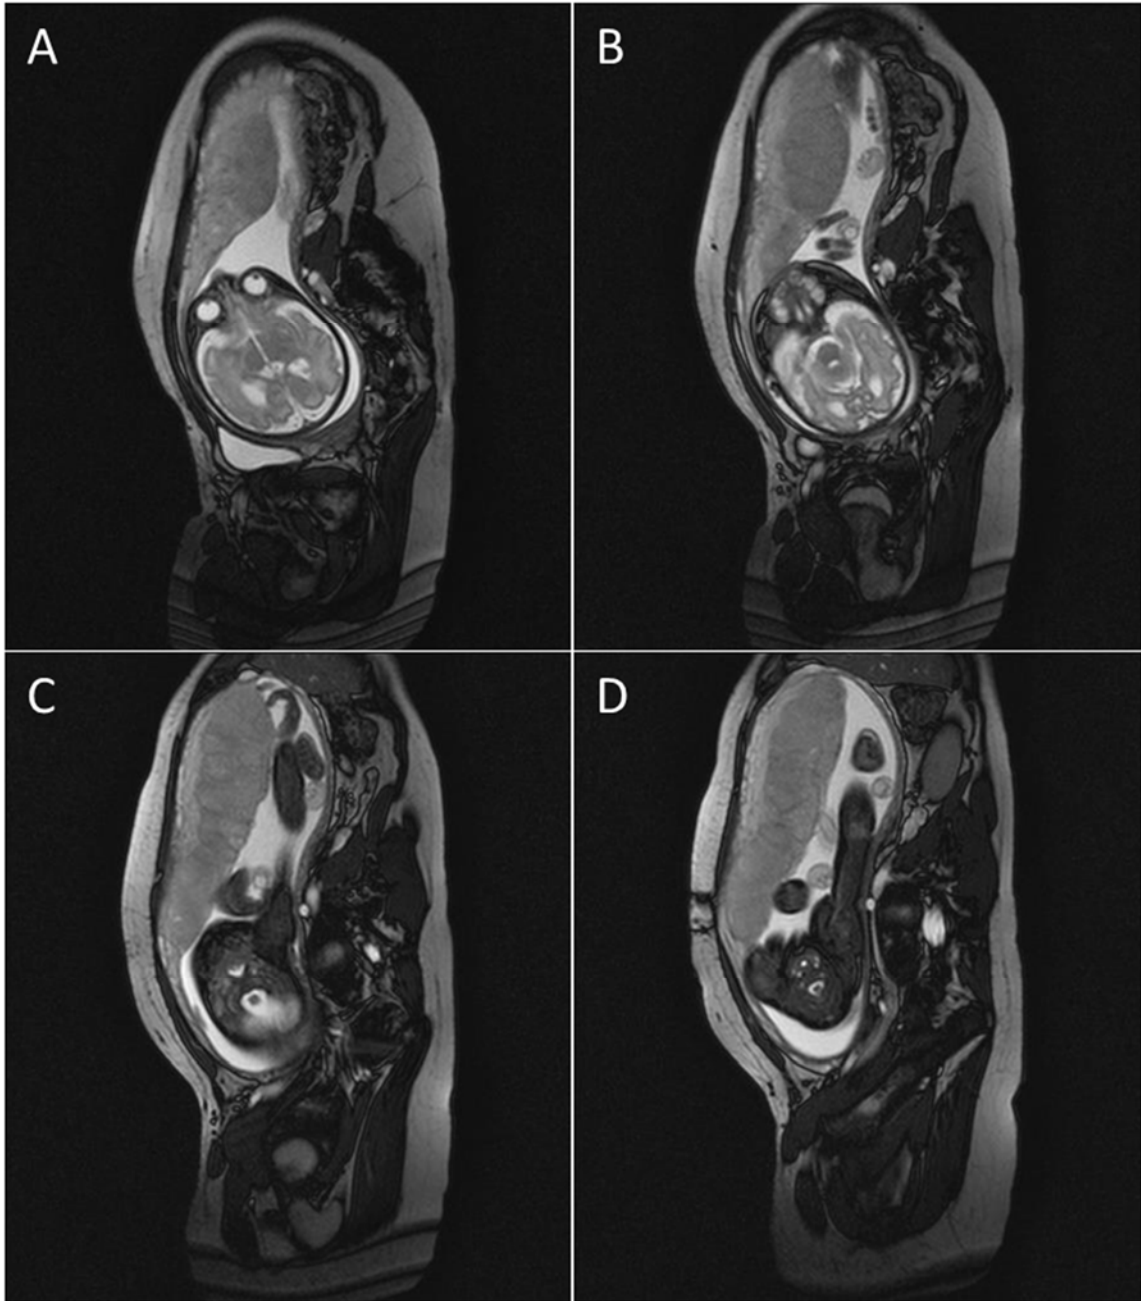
Transverse Plane MRI Scans of Human Pregnancy
